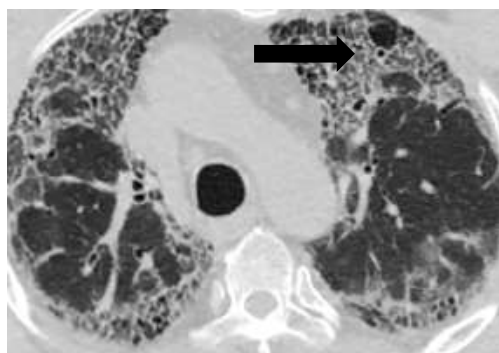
Honeycombing. Axial HRCT image of the chest showing honeycombing (arrow).
